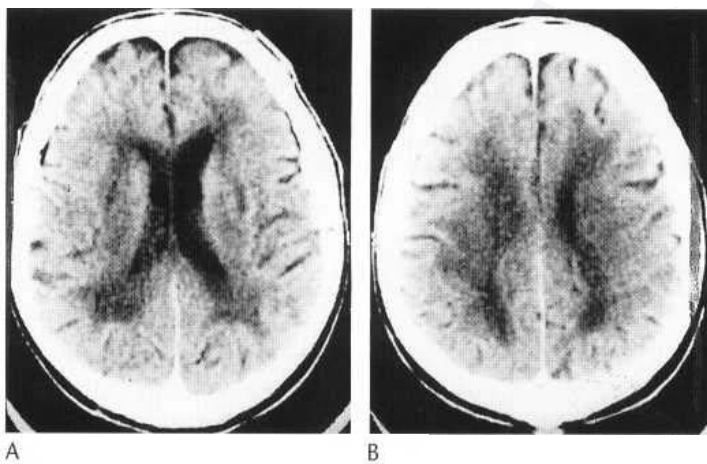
(A,B) CT of elderly demented patient. Cortical atrophy is mild but there are extensive areas of patchy low density in the deep cerebral white matter. Binswanger's disease.
